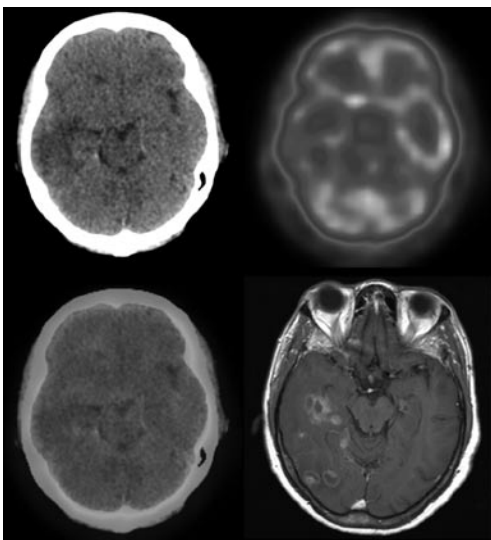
Figure one shows CT, PET, fused PET/CT, and MRI (T1 sequence post Gadolinium) transaxial images acquired 76 minutes following 12 mCi of 18F-FDG demonstrate hypometabolism in the right temporal lobe which correlated to the largest lesion described on MRI.
